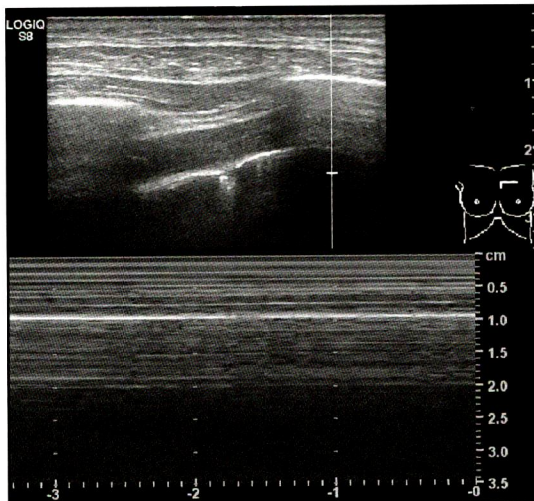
Normal lung a. in B-mode : Transthoracic sonography revealed hyperechoic pleural line in between two ribs and to-and-fro movement of the visceral pleura on parietal pleura in normal aerated lung “lung sliding” during real time study and “comet tail artifact” synchronized with respiratory movement. b. in M-mode : The motionless portion of the chest above the pleural line creates horizontal wave and the sliding below the pleural lines creates a granular pattern seen as waves crashing in onto the sand “seashore sign”
